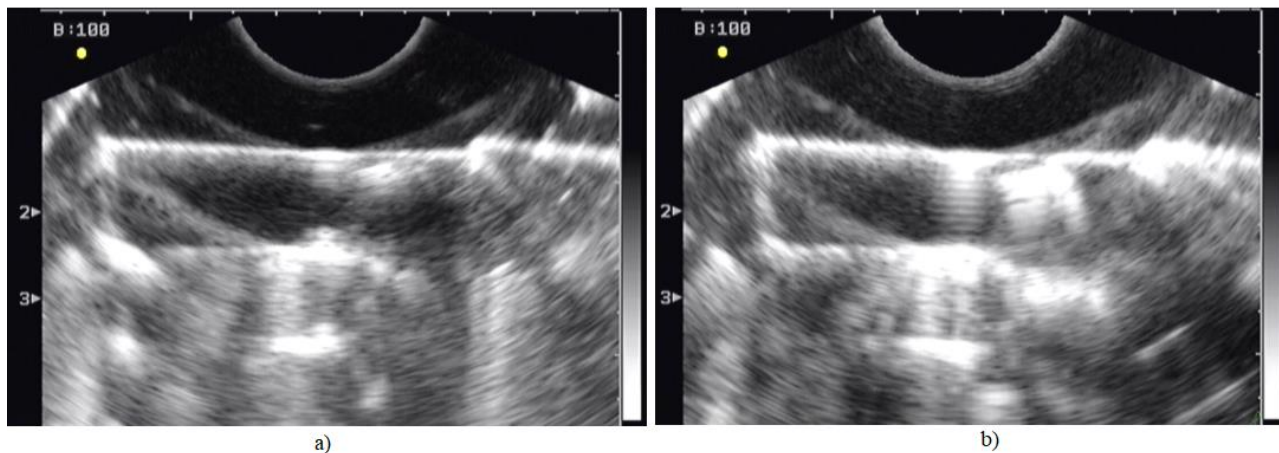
With 6.5 MHz endocavity ultrasound probe acquired images of samples irradiated with 0.5 Gy (a) and 2 Gy (b) dose.
